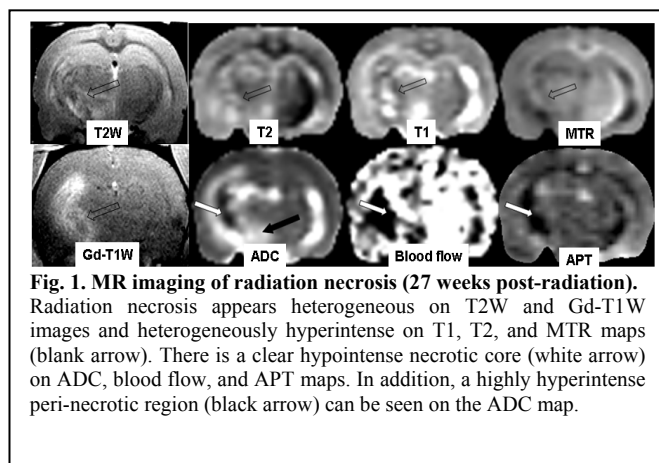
MR imaging of radiation necrosis (27 weeks post-radiation). Radiation necrosis appears heterogeneous on T2W and Gd-T1W images and heterogeneously hyperintense on T1, T2, and MTR maps (blank arrow). There is a clear hypointense necrotic core (white arrow) on ADC, blood flow, and APT maps. In addition, a highly hyperintense peri-necrotic region (black arrow) can be seen on the ADC map.
